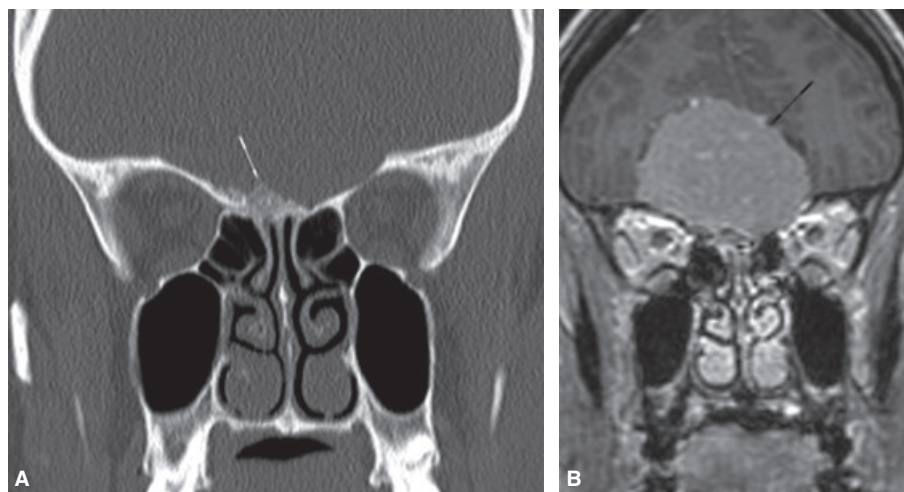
(A) Coronal CT image shows the focal hyperostosis in both cribriform plates (white arrow). (B) Contrast enhanced T1-weighted image shows a giant olfactory groove meningioma (black arrow). No pathology in nasal and paranasal regions was observed.
